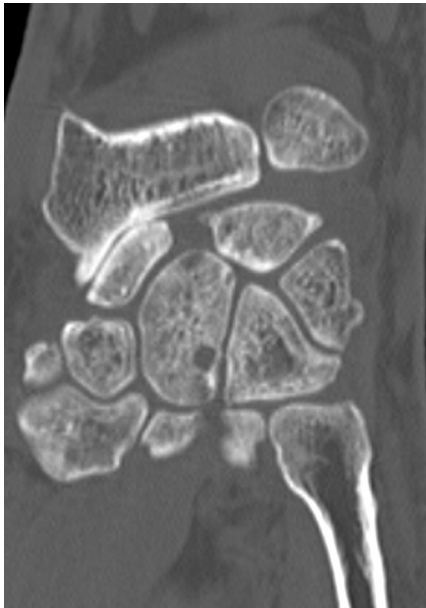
Coronal CT slice of the right wrist.
